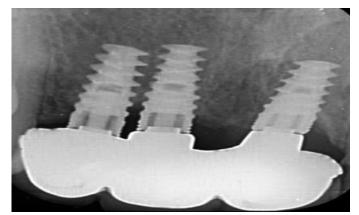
One-year post-operative periapical radiograph
